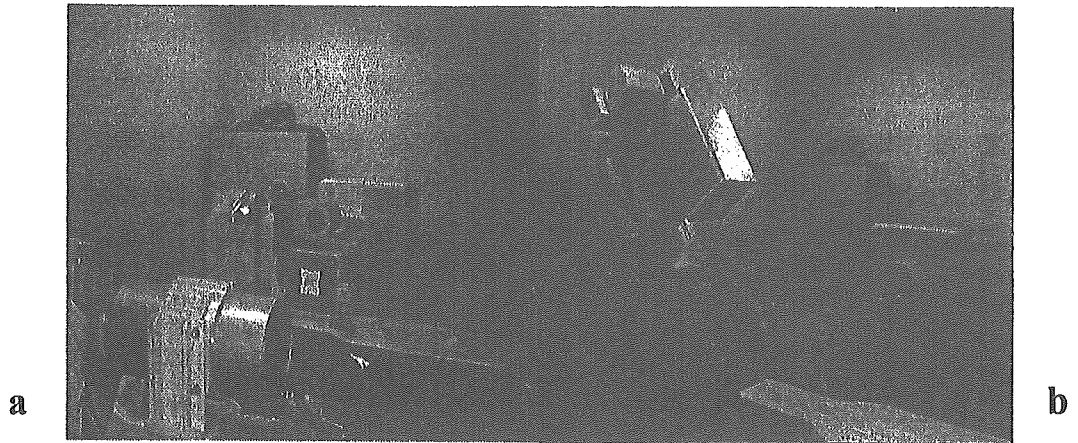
The micro-angiographic equipment that we developed. High-voltage power X-ray source a and a detecting system with a high spatial resolution (25 μ m) and high sensitivity (100 times of CCD camera) b.
